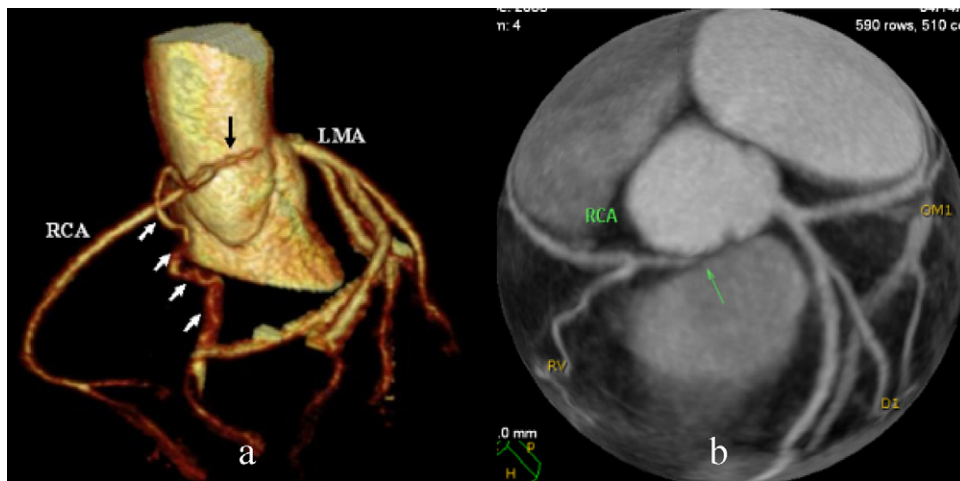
(a) Computed tomography angiogram revealing congenital atresia of the right coronary ostium. A hypoplastic proximal right coronary artery ends blindly (black arrow). Collateral formation from left coronary system to the right coronary artery was observed (white arrows). (RCA, right coronary artery; LMA, left main artery.) (b) Hypoplastic proximal right coronary artery that ends blindly (arrow) and its relationship with the right coronary cusp.
